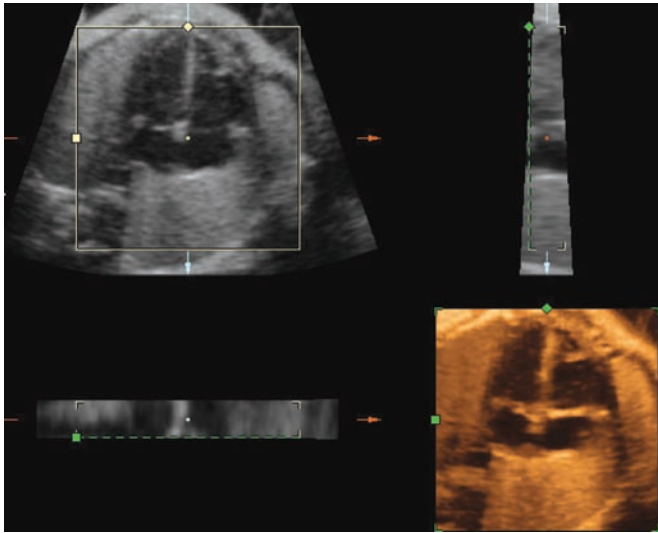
VCI-A of the fetal heart (29 weeks). This technique shows the same anatomical region as in the 2D ultrasound (upper left), but the contrast is better in VCI-A (lower right).
